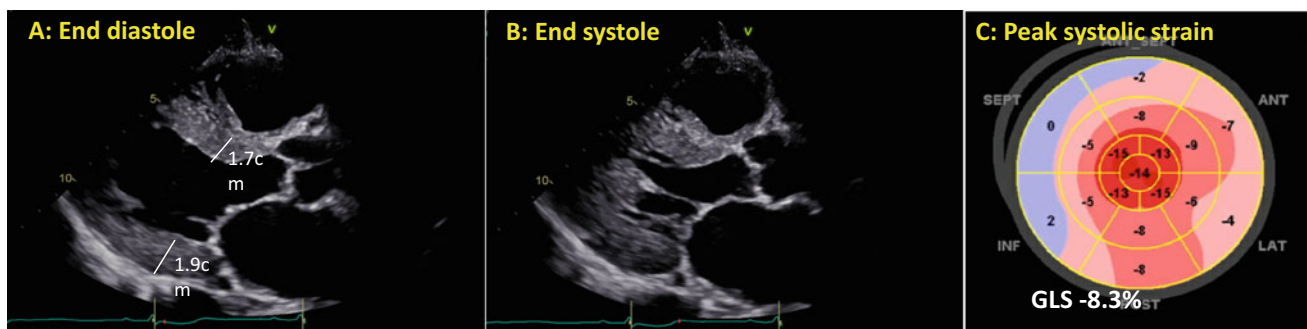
2D transthoracic echocardiogram with strain. Parasternal long-axis view at a end diastole and b end systole showing severe concentric left ventricular hypertrophy and increased ventricular mass. Interventricular septal thickness 1.7 cm, posterior wall thickness
